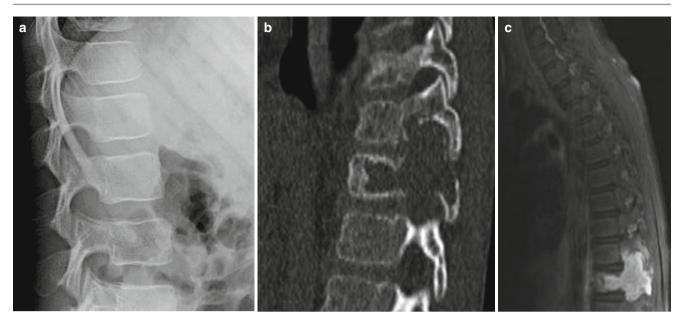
(a) Radiograph of LCH affecting the lumbar spine. Lytic lesion in the body and pedicles of a vertebra can be seen. Vertebra shape is maintained. (b) MPR CT of the same case as previous figure.
